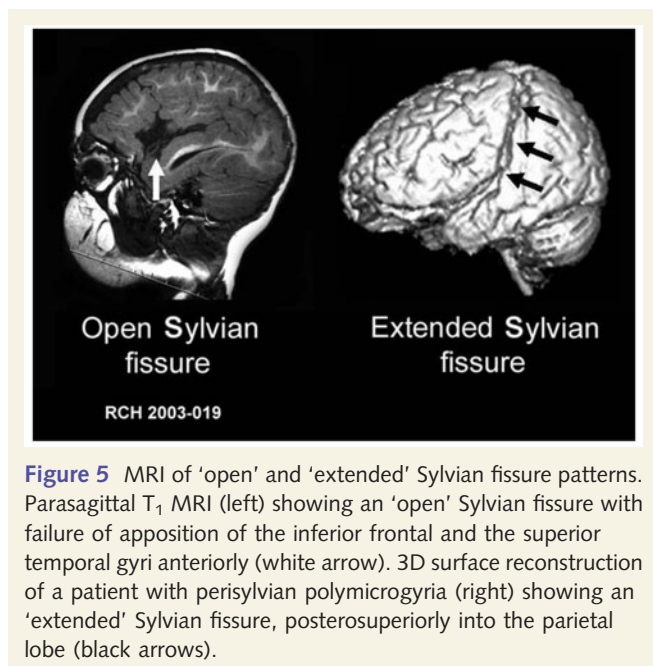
MRI of 'open' and 'extended' Sylvian fissure patterns. Parasagittal T₁ MRI (left) showing an 'open' Sylvian fissure with failure of apposition of the inferior frontal and the superior temporal gyri anteriorly (white arrow). 3D surface reconstruction of a patient with perisylvian polymicrogyria (right) showing an 'extended' Sylvian fissure, posterosuperiorly into the parietal lobe (black arrows).
